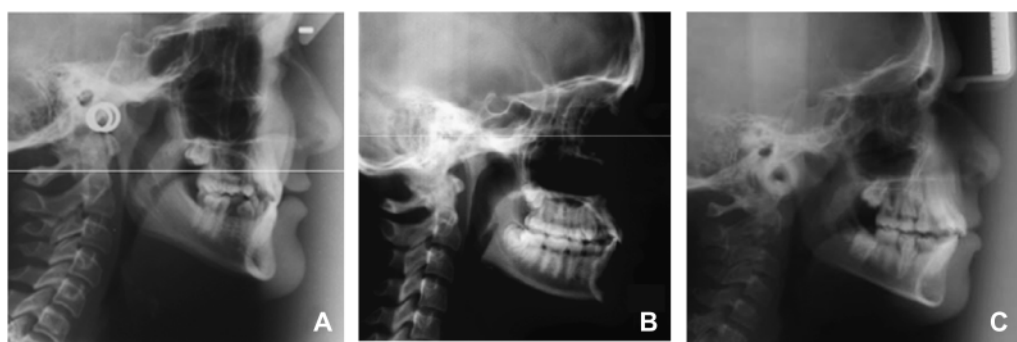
Lateral cephalometric radiographs of patients with (A) dental transposition and bridging of the sella turcica (B) dental transposition and partial bridging of the sella turcica and (C) dental transposition and no calcification of sella, although a cervical fusion between C2 and C3 can be observed (C).
